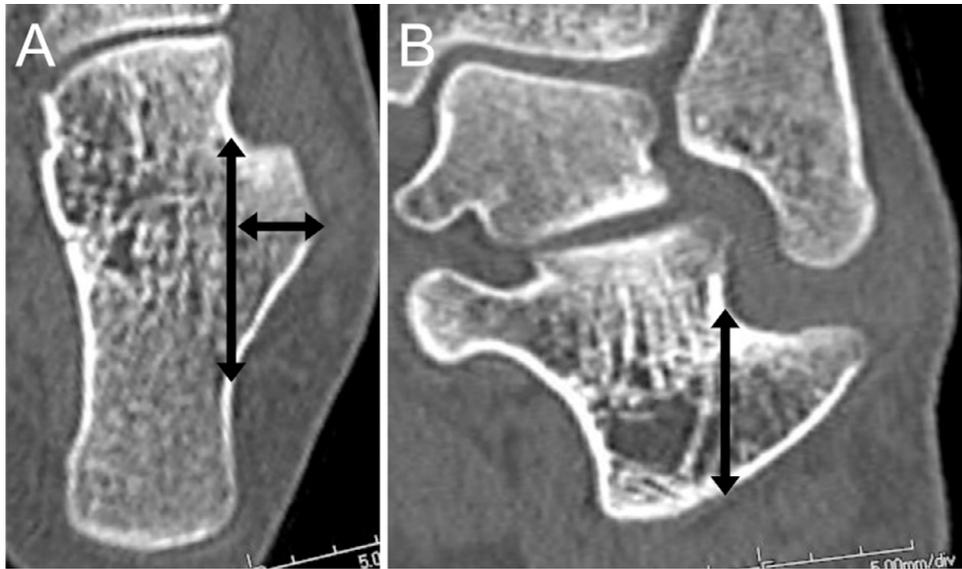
The width and length of the hypertrophied peroneal tubercle are 11 mm and 33 mm, respectively, in the axial CT image (arrows, A). The height is 17 mm in the coronal image (arrow, B).
